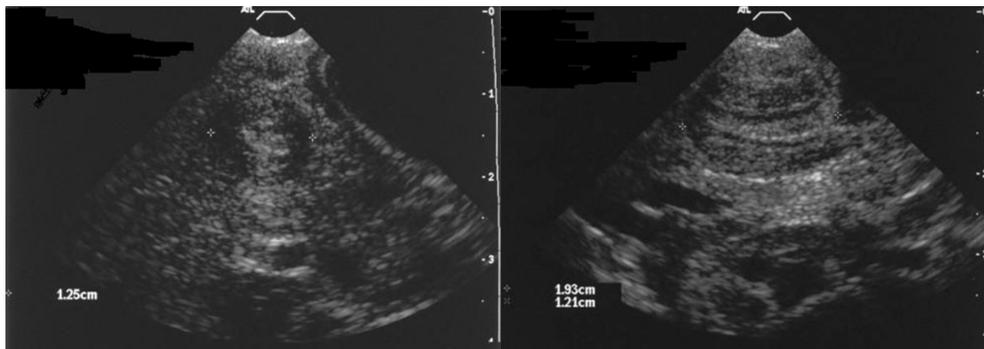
Hypertrophic pyloric stenosis – ultrasound: A cross-section; B longitudinal section
